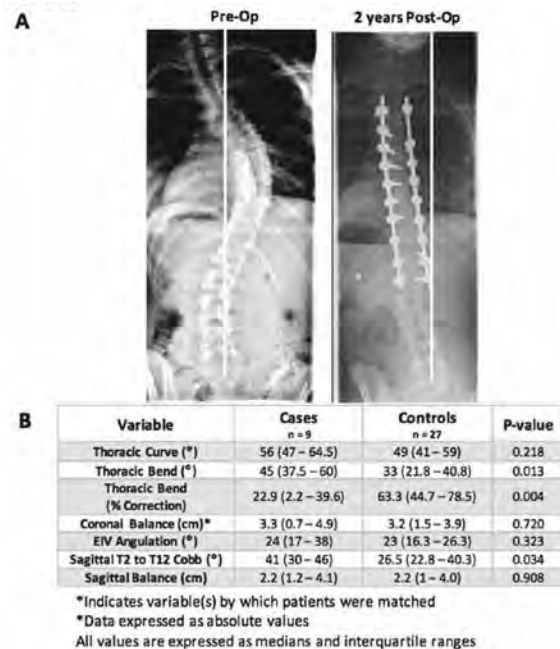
(A) Pre- and post-operative radiographs for patient with severe coronal imbalance at two-years and (B) comparison of pre-operative radiographic factors in cases versus controls.
